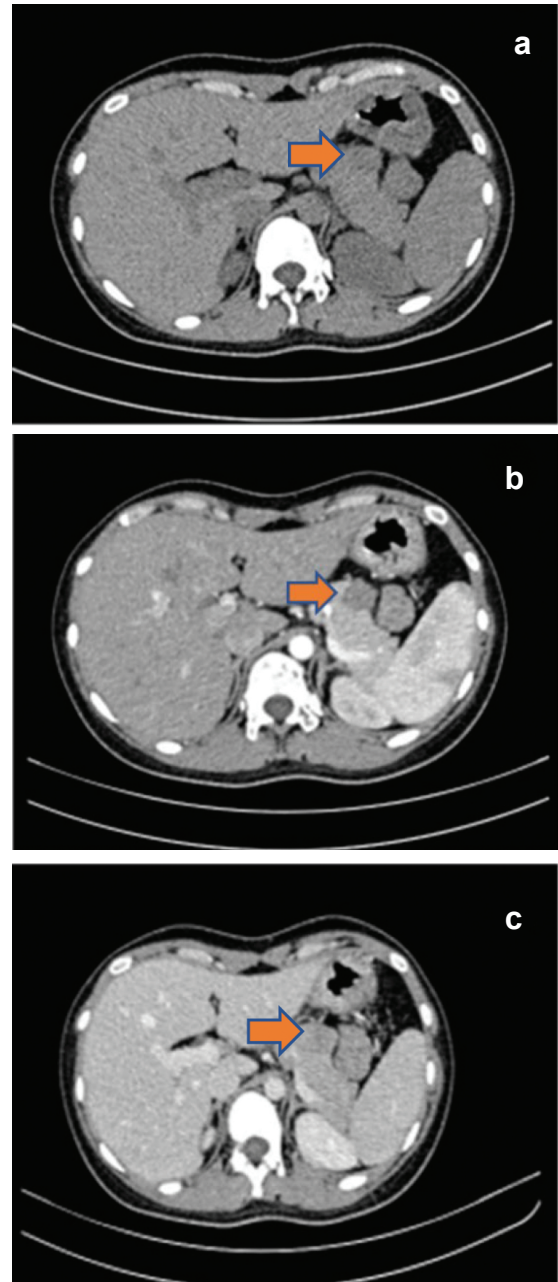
Atypical CT imaging features of small (≤ 3 cm) solid pseudopapillary tumors.
